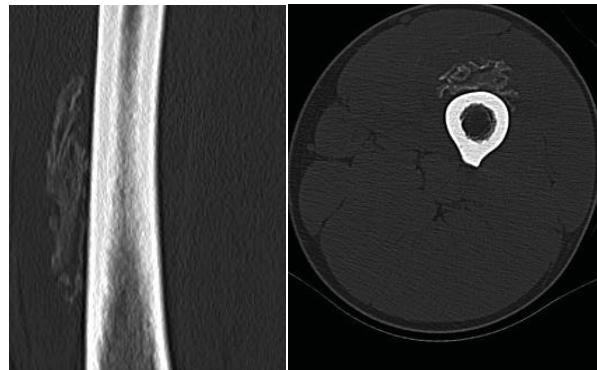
Computed tomographic (CT) scans also showed several calcific deposits arranged in rami, indicating MO.
